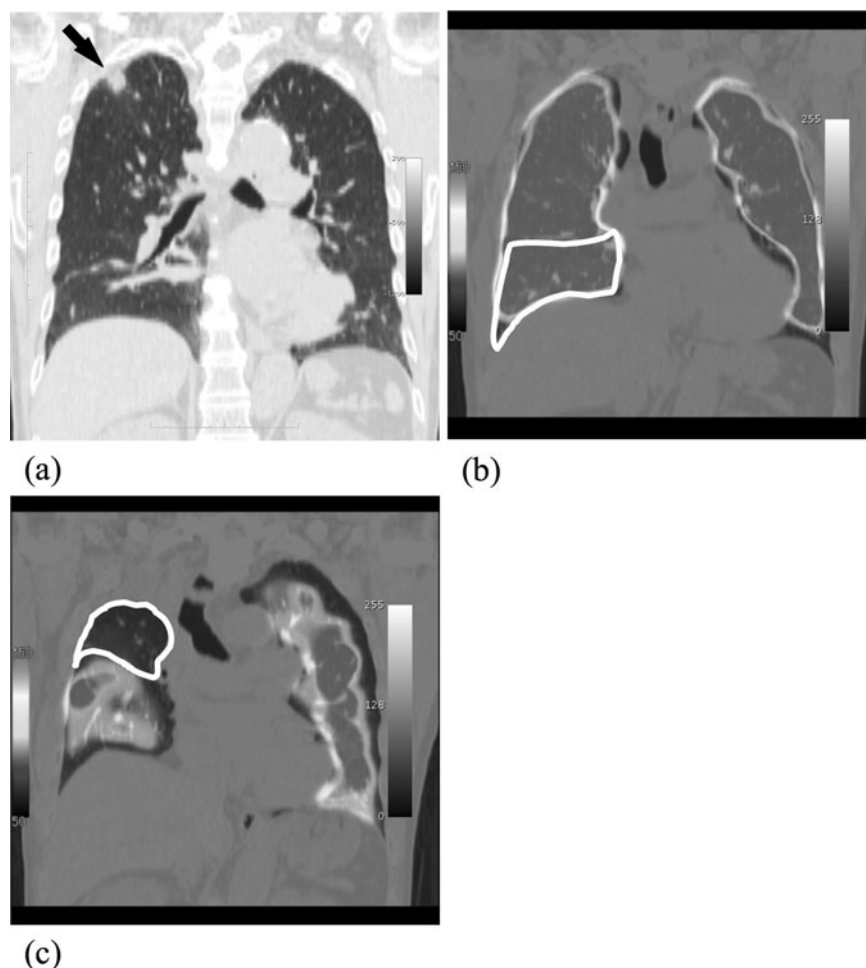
Lobectomy case. a Coronal computed tomography (CT) image before surgery, showing a tumor in the right upper lobe. b Perfusion single-photon emission CT (SPECT)/CT before the right upper lobectomy. The image of the right middle lobe is surrounded by a solid line. The forced expiratory volume in 1 second (FEV_1) of the right middle lobe was 0.351. c Perfusion SPECT/CT after the right upper lobectomy. The image of the right middle lobe is surrounded by a solid line. The FEV_1 of the right middle lobe was decreased to 0.131
